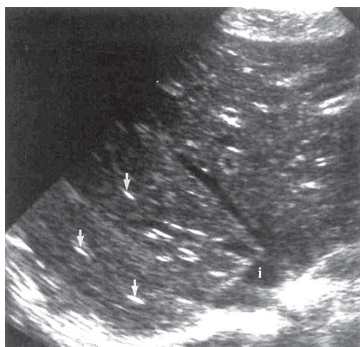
Ultrasound: Starry night appearance of acute hepatitis
